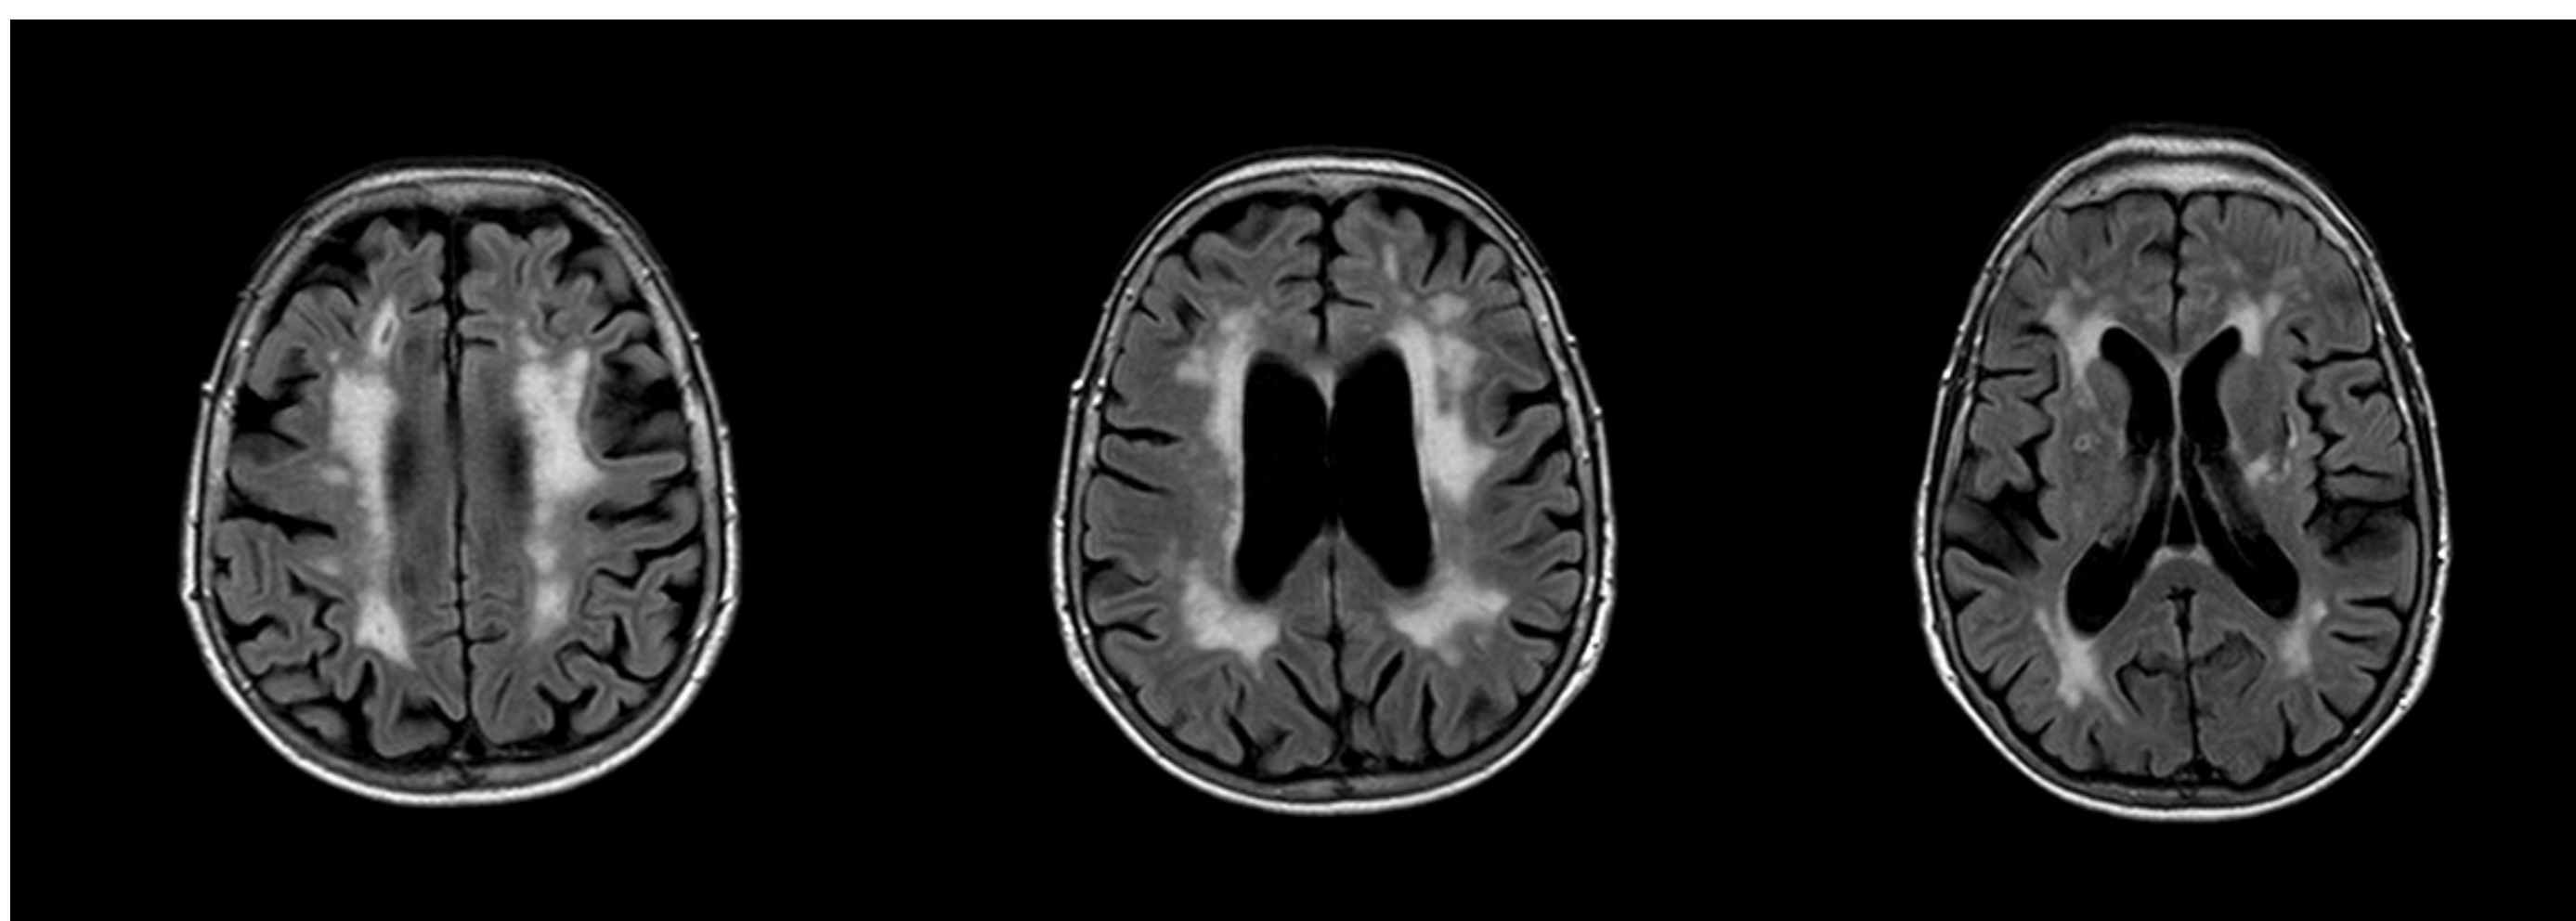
MRI T2/FLAIR sequences: multifocal, confluent hyperintensities in the deep and periventricular white matter
